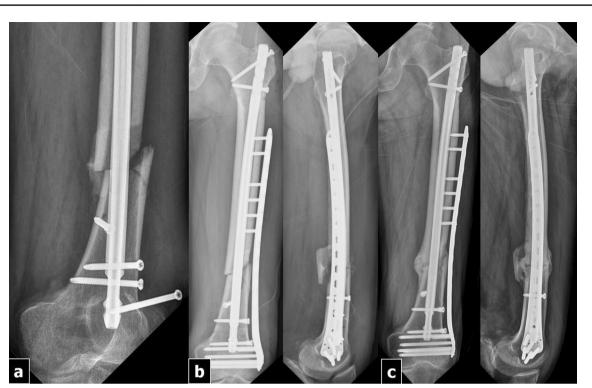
a Follow-up radiograph at 6 weeks, showing fixation failure with fracture displacement. b Antegrade nailing was performed again, followed by additional augmentative minimally invasive plating. c Radiographs obtained after 1 year shows healing of the fracture
